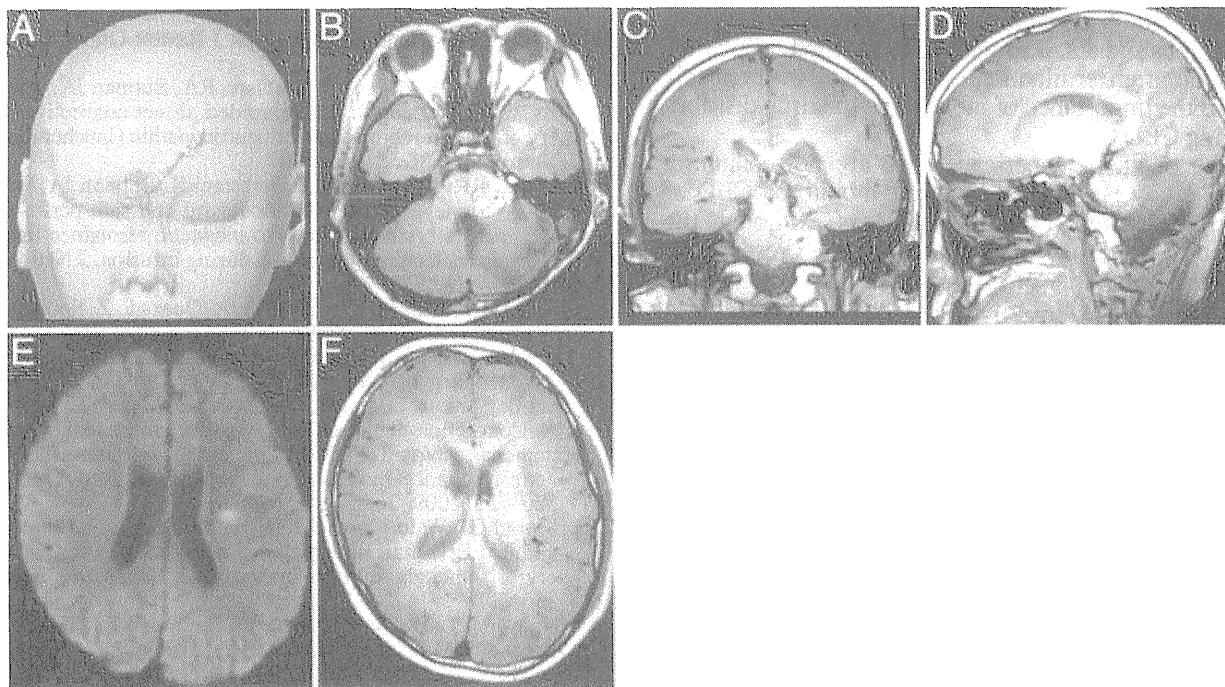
Relationship between the enhanced tumor mass and distribution of CED Gd-DOTA. A–D and F: Images produced using the iPlan stereotactic software. The contrast-enhanced T1-weighted MR image are overlapped with the T1-weighted MR images obtained at the end of CED. The tumor is indicated by the *red* and the distribution of Gd-DOTA by *yellow*. The images in A–D demonstrate the relationship between the tumor and distribution of Gd-DOTA at the end of CED. Diffusion-weighted MR images, obtained when the patient developed mild right hemiparesis (E), showing a high-intensity lesion in the left corona radiata where there was a reflux of infused Gd-DOTA at the end of infusion (F).
